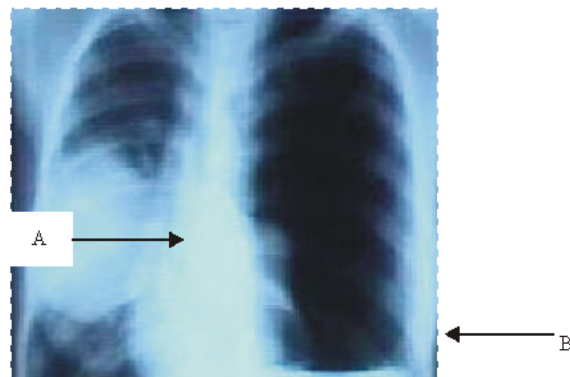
Chest X-ray revealed the presence of (A) a large rounded homogenous well circumscribed nodular opacity in the right lung and (B) pleural effusion (infected chest fluid) in the left side of the chest resulting from infected ruptured hydatid cyst and empyema of the chest
